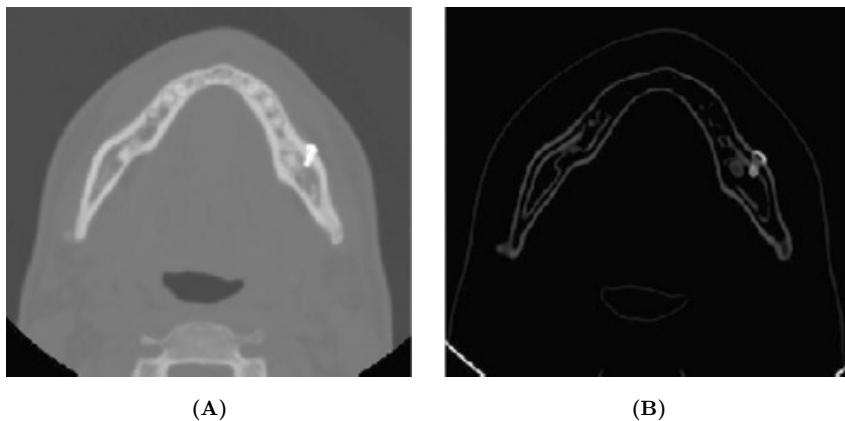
Craneofacial CT image with highlighted boundaries: (A) Original CT image. (B) Boundaries detection in A with the gradient size calculation in directions X, Y, Z .
